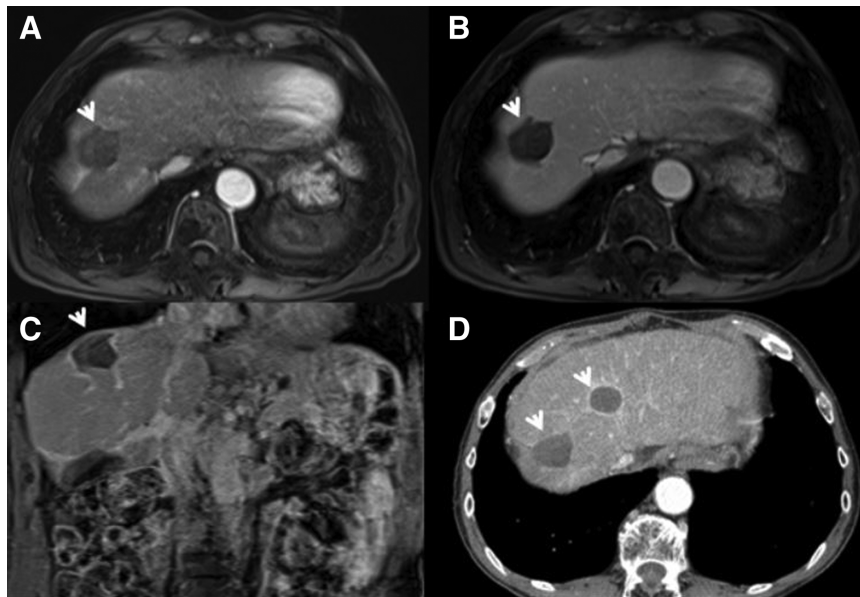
A 72-year-old man with microwave ablated colorectal liver metastasis (CRLM) on VIII-VII hepatic segment. Magnetic resonance imaging [(A) volume-interpolated breath-hold examination T1 weighted fat sat during arterial phase of contrast study in axial plane; (B) volume-interpolated breath-hold examination T1 weighted fat sat during portal phase of contrast study in axial plane; (C) volume-interpolated breath-hold examination T1 weighted fat sat during portal phase of contrast study in coronal plane] study shows no residual disease and no diaphragm injury and pneumothorax. In (D) Multidetector CT scan during portal phase of contrast study follow-up at 1 years post a new microwave ablation treatment for another CRLM: no residual disease and no diaphragm injury and pneumothorax.
